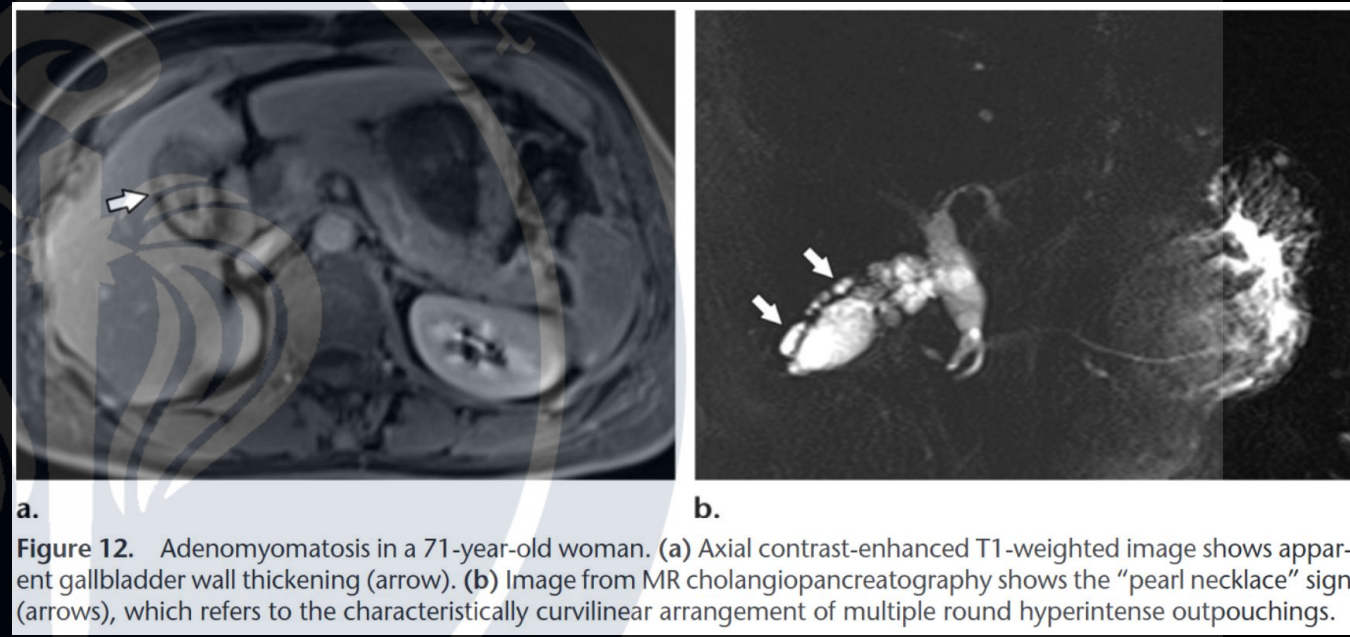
Adenomyomatosis in a 71-year-old woman. (a) Axial contrast-enhanced T1-weighted image shows apparent gallbladder wall thickening (arrow). (b) Image from MR cholangiopancreatography shows the “pearl necklace” sign (arrows), which refers to the characteristically curvilinear arrangement of multiple round hyperintense outpouchings.
